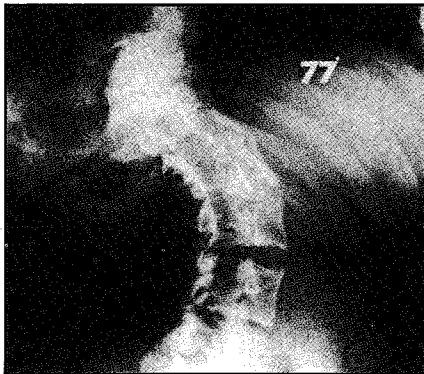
Pre operative A-P radiograph of patient at age 15 years and 1 month. The coronal curve has progressed to 77 degrees.
